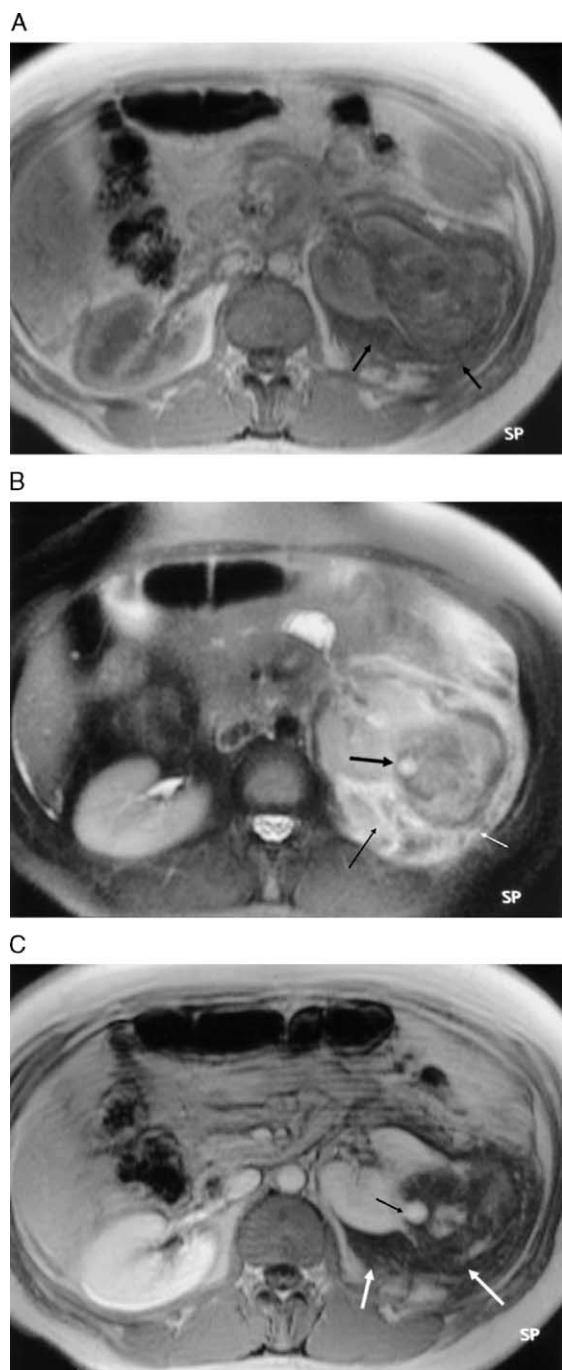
Perinephric fluid extravasation as a result of the biopsy of cystic renal cell carcinoma. (A) Axial T1-weighted SGE image (TR/TE/FA, 165/4.2/80) revealing perinephric fluid collection in the perirenal space with a hyper/hypointense mixed signal (arrows). (B) Axial T2-weighted fat-saturated T2-weighted half-Fourier single-shot fast spin echo images (TR/TE,  $\infty$ /90) demonstrating perinephric fluid collection with a hypo/hyperintense mixed signal (thin arrows) and a hyperintense mural nodule within the cystic mass (thick black arrow). (C) Delayed postcontrast axial T1-weighted SGE image (TR/TE/FA, 150–180/4.2/80) showing that the perinephric fluid collection is hypointense relative to the kidney and that the mural nodule reveals intense enhancement (thin black arrow).
